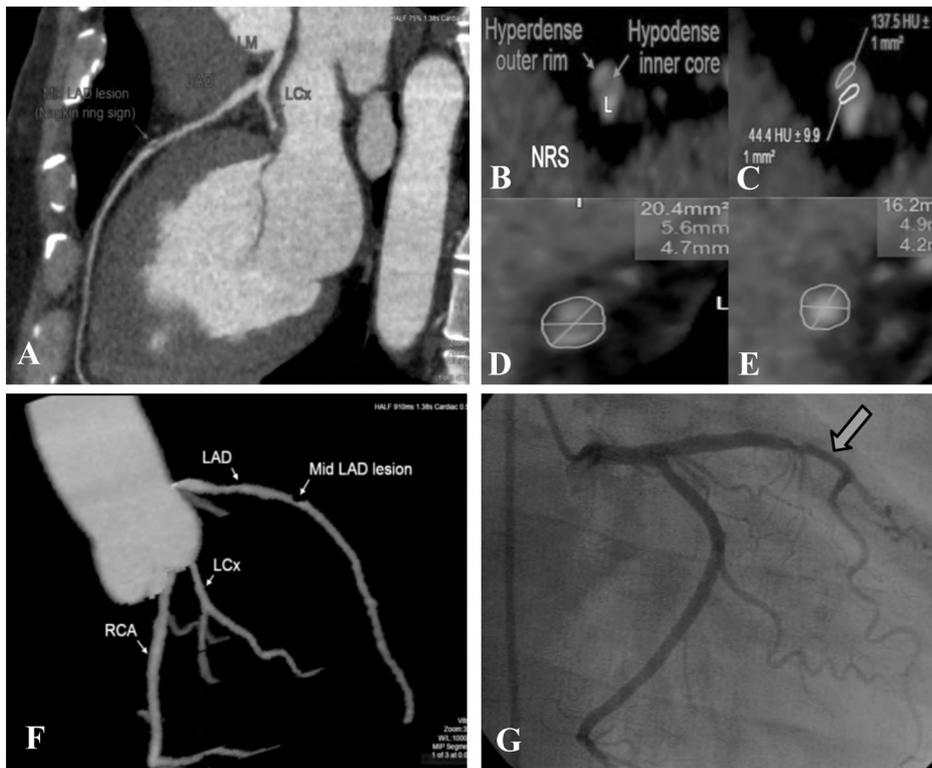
52-year-old male patient, smoker with hypercholesterolemia complaining of recurrent attacks of typical chest pain on moderate exertion (class III); with history of NSTEMI and ICU admission 10 days before coronary CT examination. (A) Curved multiplanar reconstructed image showed moderate mid-LAD lesion exerted by non calcified plaque, cross sectional analysis of showed NRS with hypodense core and hyper dense outer rim (B) ROI was applied at hyper dense outer rim and CT number was obtained  $137.5 \pm 15.9$  HU (C): ROI was applied at hypodense core and CT number was  $44.4 \pm 9.9$  HU. Positive remodeling was obtained from the ratio of lesion plaque area ( $20.4 \text{ mm}^2$ ) at (D) To referential area ( $16.2 \text{ mm}^2$ ) at (E), In the case represented = 1.25. (F): CTA reconstruction of left coronary arteries in the RAO CAU view showing mid LAD lesion. (G) Invasive coronary angiography RAO CAU view confirmed moderate mid-LAD lesion (blue arrow).
